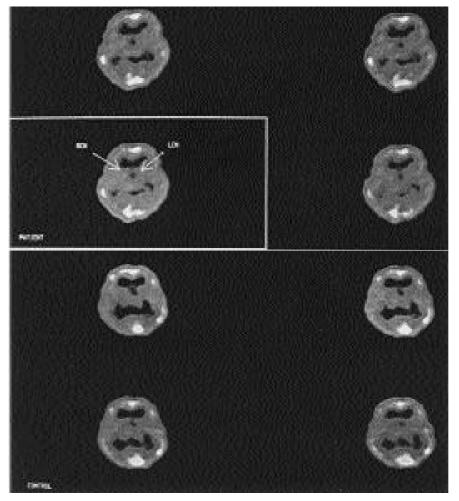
99m-technetium-hexamethylpropyleneamine oxime (Tc^{99m} - HMPAO) brain SPECT scan transverse section images from a FM patient and a control subject. There is high blood flow to the right and left caudate nuclei (RCN, LCN) compared to the normal control.
